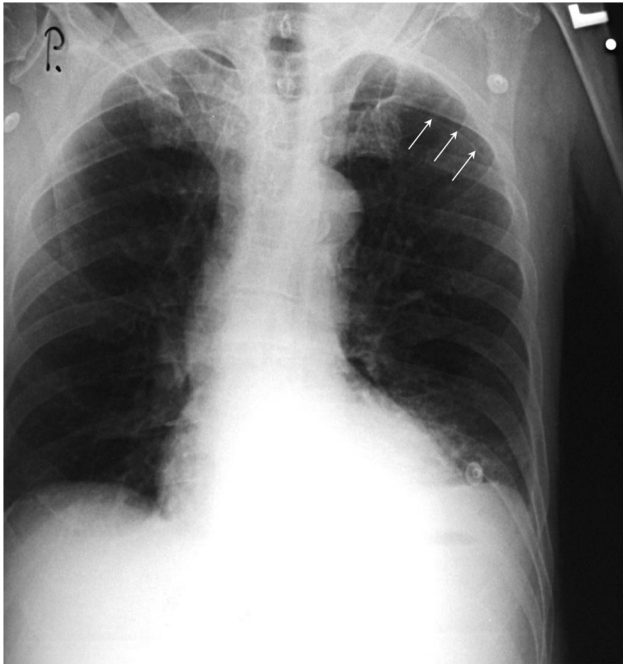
Chest radiograph shows a left-sided apical pneumothorax (arrows) and a homogenous opacity at the base of the left lung. The upper margin of the opacity is well defined and sharp, whereas the lower margin is indistinguishable from the adjacent left hemidiaphragm. As the left costophrenic angle is well preserved and the gastric air bubble is not clearly visible, this might suggest elevation of the left hemidiaphragm. However, the lateral displacement of the dome with a steep lateral slope and gradual medial slope requires differentiation from pleural effusion (subpulmonic effusion).
